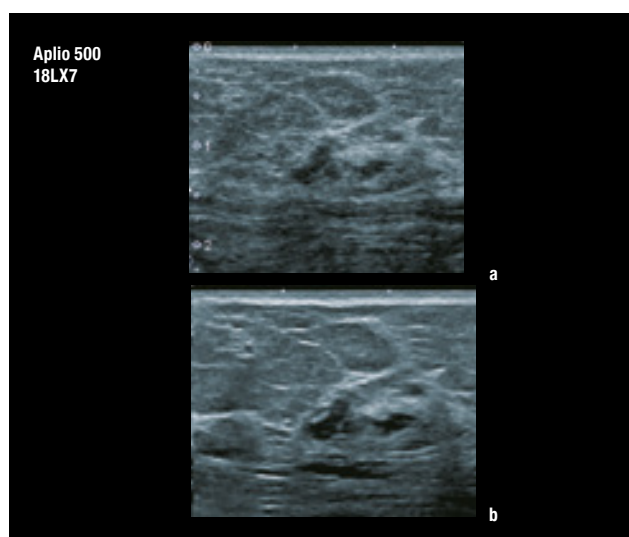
Comparison of image quality on breast ultrasound between 18LX7 (a) and i24LX8 (b). Using the ultra-high frequency transducer, the internal structure of the hypoechoic region can be visualized clearly (b).
